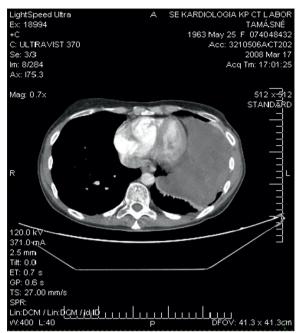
The chest CT revealed a giant tumour measuring 170×103×180 mm, protruding from the left pulmonary hilus with trans-phrenic extension to the level of the pancreas.
